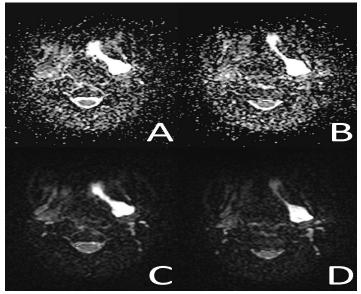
DWI-TRACE images at b=1000s mm-2 (TR:5000, TE:101) (A-B), and ADC images (TR:5000, TE:101) both revelead a lesion with a high signal as it was in T2W sequence (C-D).
